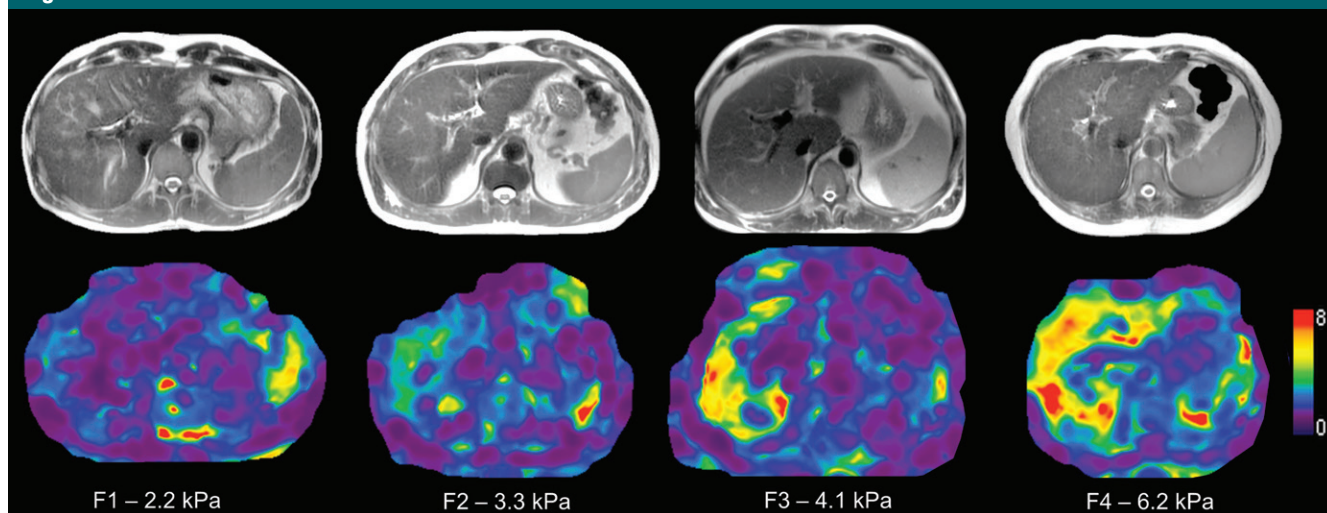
Transverse T2-weighted half-Fourier acquisition single-shot turbo spin-echo, or HASTE, anatomic images (top) and transverse MR elastograms (bottom) depict increasing liver stiffness with increasing fibrosis in patients with chronic hepatitis C virus infection: stage F1 in a 51-year-old man, stage F2 in a 67-year-old man, stage F3 in a 46-year-old man, and stage F4 in a 65-year-old woman. Anatomic images depict no significant liver nodularity in patients with stage F3–F4 fibrosis, while MR elastograms reveal increasing stiffness (yellow and red colored areas).
